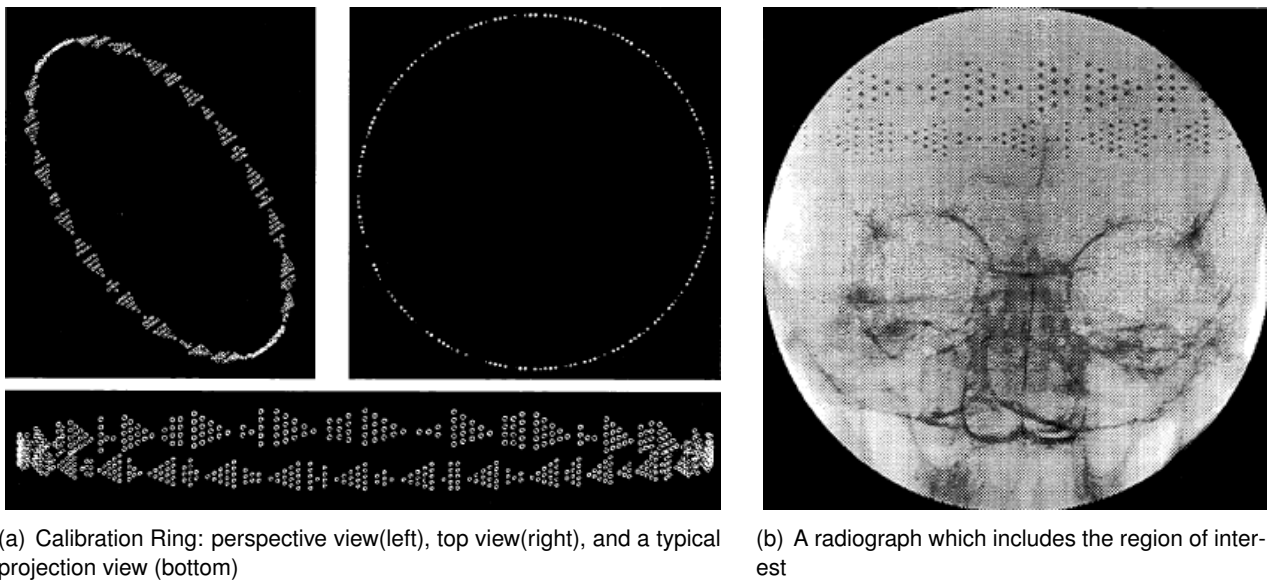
The calibration ring used for C-arm pose estimation (a) and an appropriate radiograph (b) [NBHM*96].
